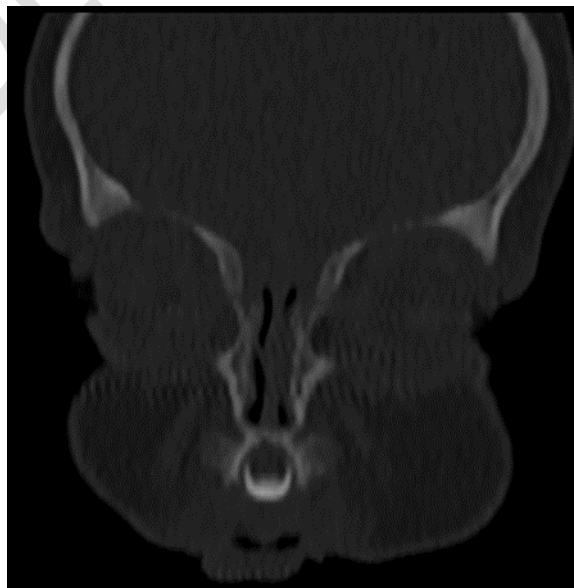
CT scan of the facial mass in coronal section in the bone window showing the presence of a central median incisor
